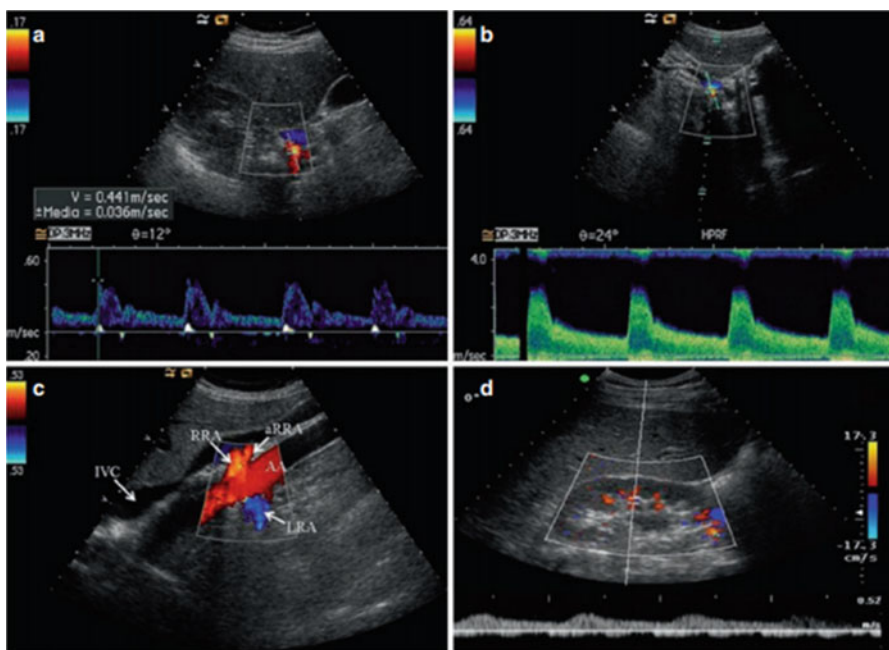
In the vascular lab, Doppler ultrasound can be used to assess flow velocity in the renal arteries, as demonstrated in panels a and b. Panel c demonstrates the inferior vena cava (IVC), abdominal aorta (AA), right renal artery (RRA), left renal artery (LRA), and an accessory right renal artery (aRRA). Trained clinicians at the bedside can easily assess the aorta and inferior vena cava. Panel d shows color and pulsed Doppler imaging of intrarenal arteries
